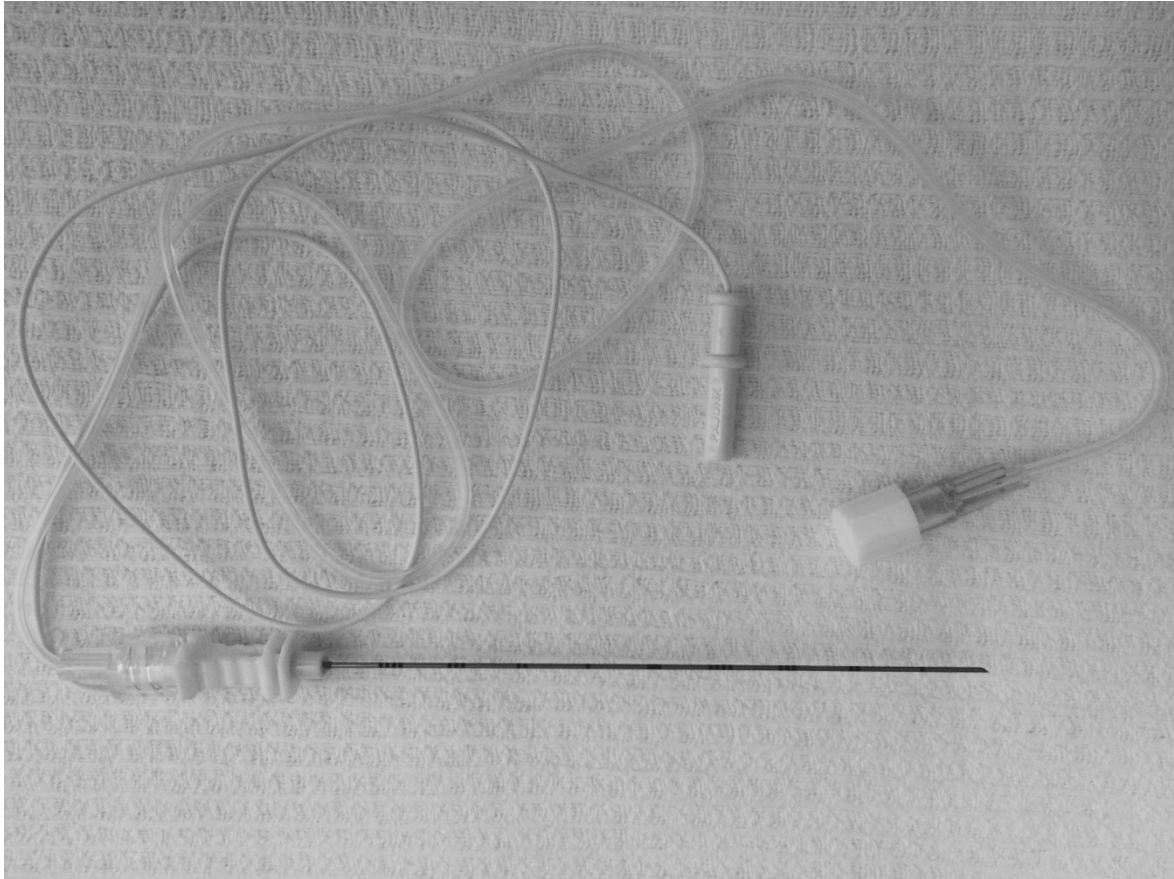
Picture of a uniplex 25 G Up 3/100 face tip needle with adaptable injection tube for aspiration and injection of the study medication. The cannula is provided with an ascending length indication in intervals of 1 cm for injection depth measurement. The cannula has a “cornerstone” surface (structured for ultrasound reflection for better identification of the needle during for Ultrasound) and has a connector for nerve stimulation (both not used in this study).
